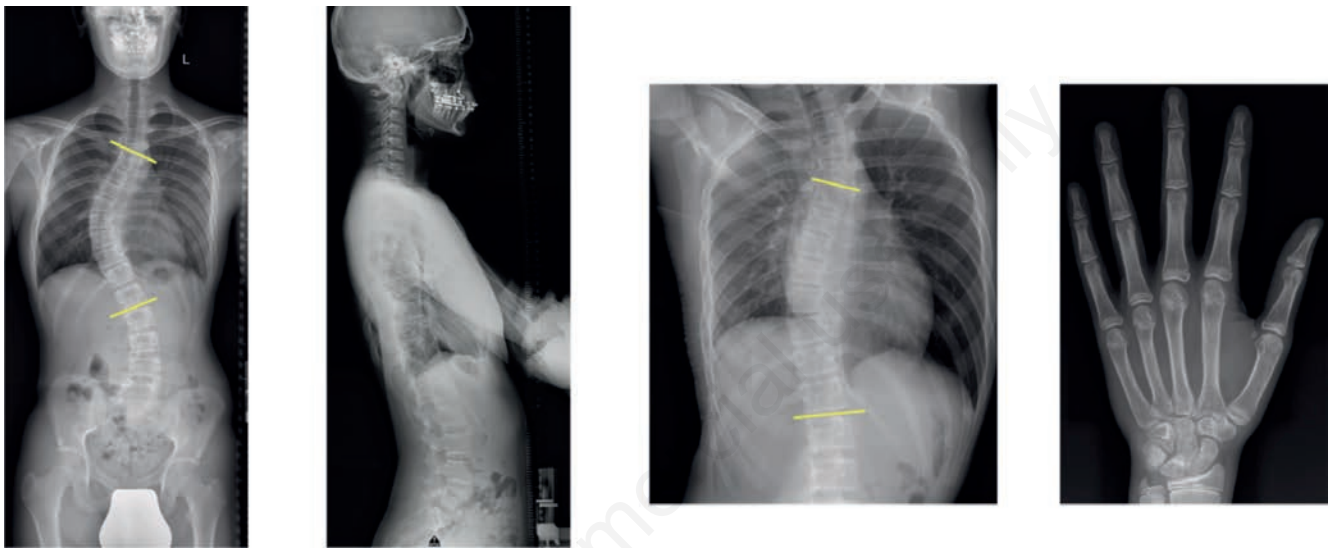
Male, 13 years old. Pre-operative X-rays: thoracic right convex curve Lenke 1B 43° Cobb, 18° on supine side bending, Risser 1, Sanders 3.
